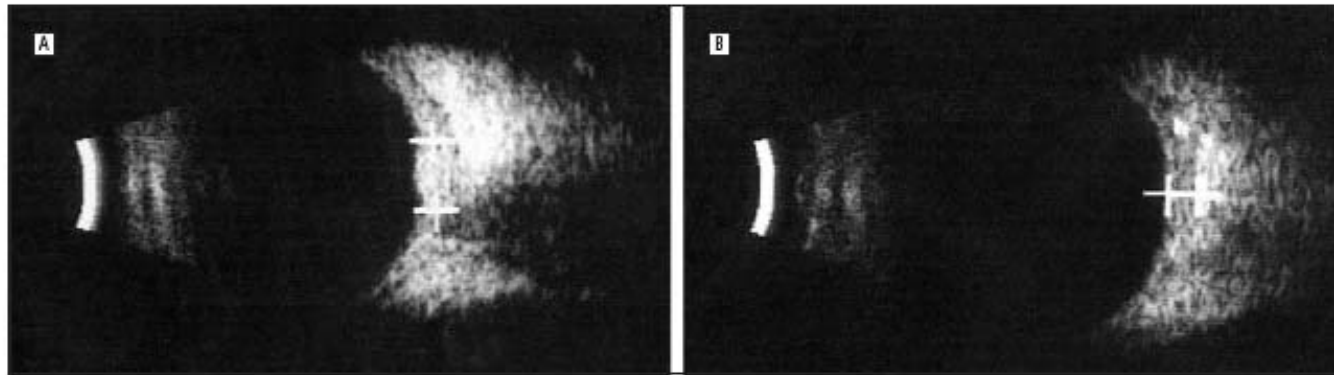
Ultrasonographic study, A, showing a solid choroidal lesion, high internal reflectivity, and a thickness of 2.5 mm. B, Echographic aspect 3 years after proton beam therapy. The tumor is almost flat; the patient's final visual acuity was 20/25.
